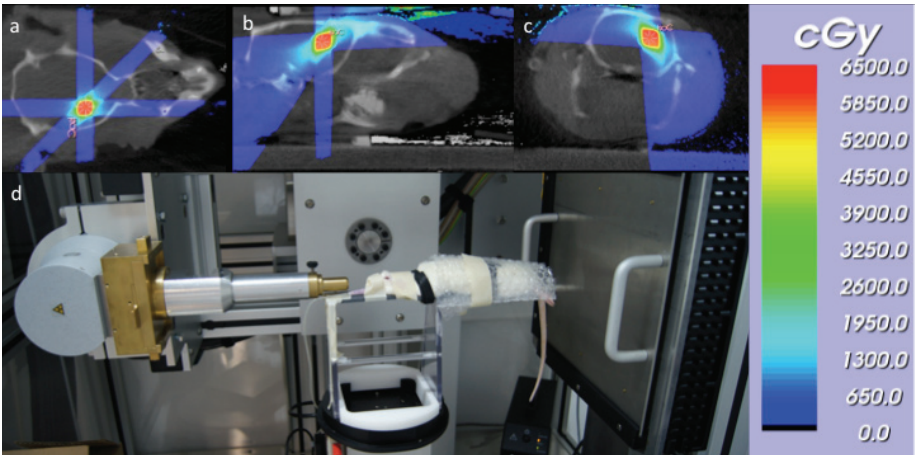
a-c: Dose plan for delivery of 60 Gy using 3 arc beams and a 3*3 mm collimator for the induction of RN. The isocenter was selected on coronal (a), sagittal (b) and axial (c) CT slices. Irradiation was performed using the SARRP system (d).
